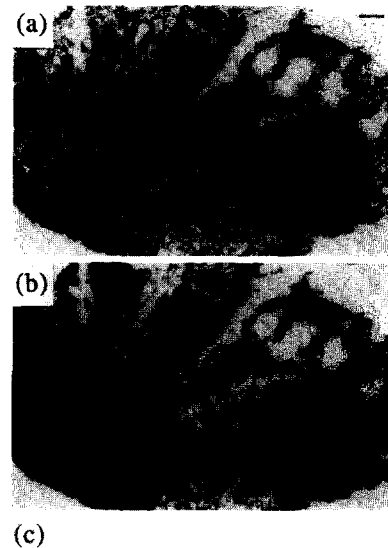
(a) Abdominal CT scan showing a homogeneous, solid tumour in the pancreatic head with distension of the duodenal C-loop. (b) Endoscopic retrograde cholangiopancreatogram showing an extended stenosis of both the pancreatic duct and the common bile duct with prestenotic dilatation of ducts. (c) Angiography of the coeliac trunk showing a markedly vascularised tumour in the region of the pancreatic head.
